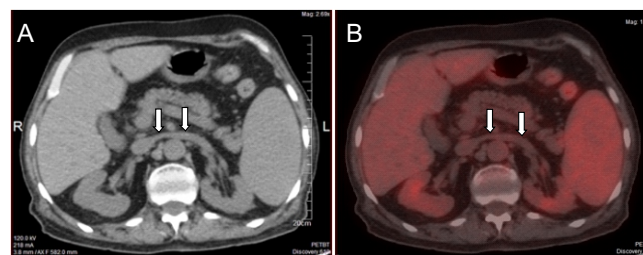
Axial plain CT (A) and fused PET/CT (B) images of normal (single, preaortic) LRV (white arrows).
